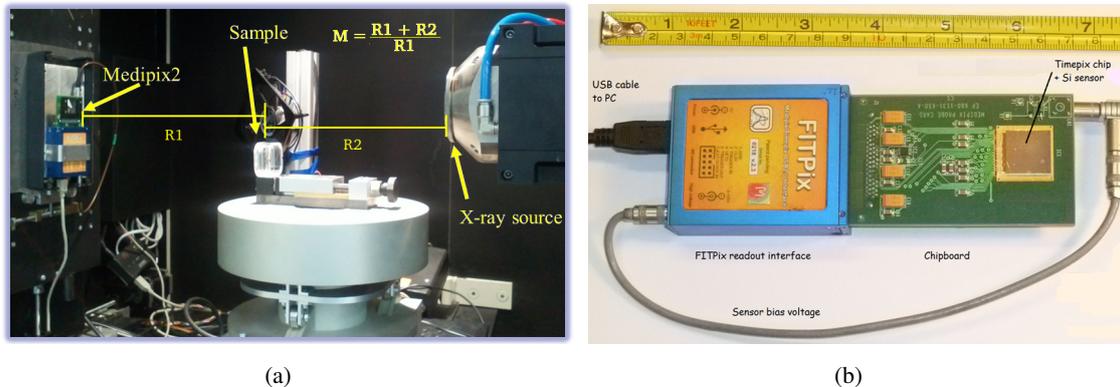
(a) Experimental setup for table-top X-ray microradiography consisting of a microfocus X-ray tube, the sample, and the imager. Magnification (M) is achieved by suitable settings of the relative distances $R1$ and $R2$. (b) Radiation camera assembled from the Timepix chip, detector chipboard and FITPix readout interface. Straightforward connection to PC via USB cable.
